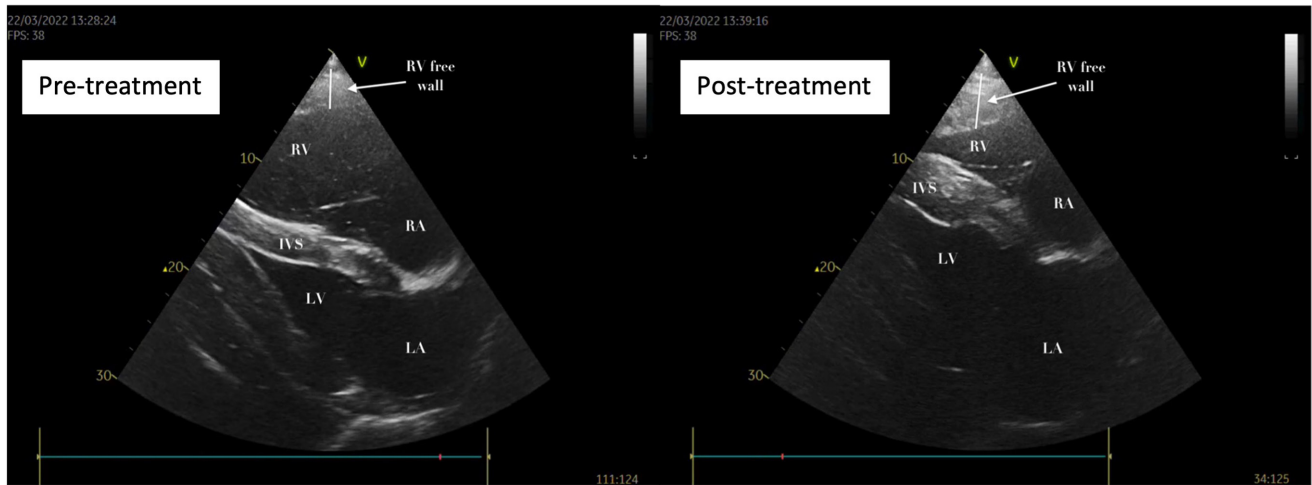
Stills from an echocardiographic examination taken during the event (pre-treatment, T 32m 00s) and after resuscitation had been performed (post-treatment, T41m 24s); RA/LA, right atrium/left atrium; RV/LV, right ventricle/left ventricle; IVS, interventricular septum (Courtesy of Professors L.E Young and J.A Keen).
